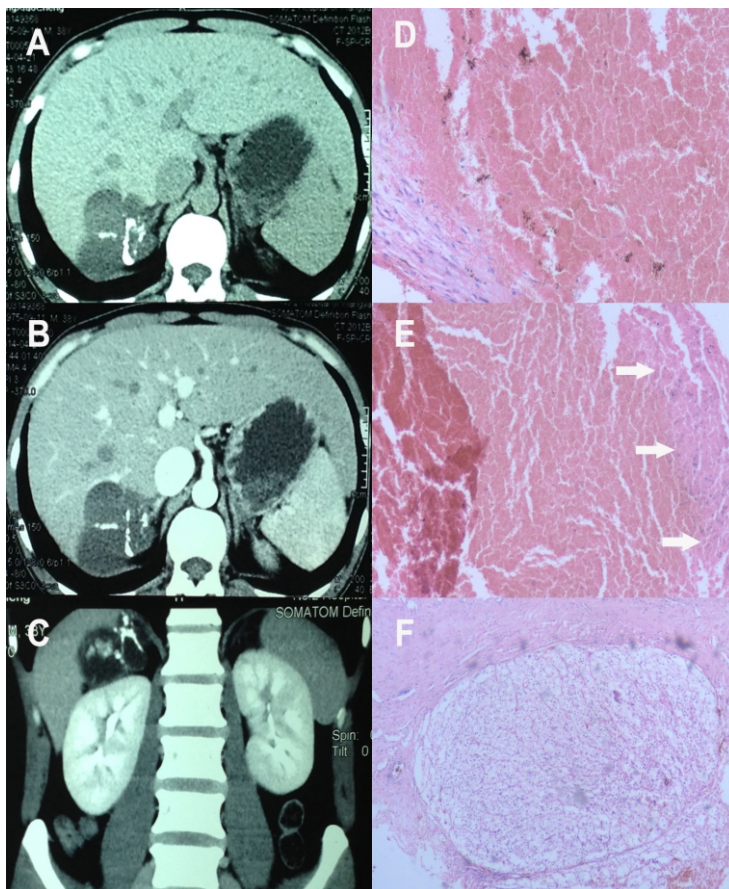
Features on CT and pathological results of adrenal hemorrhagic pseudocyst.
